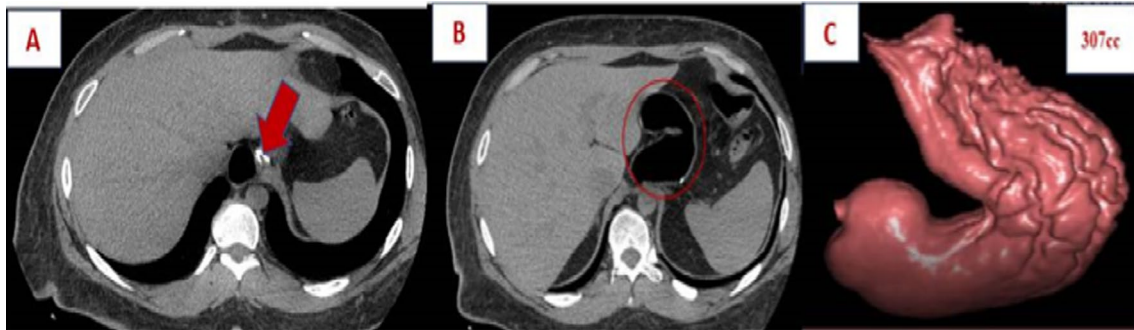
A 44-year-old obese female (BMI = 55.5) with postoperative gastric pouch volume is 307 cc. Preoperative weight and 1-year postoperative weight were 164 kg and 90 kg, respectively. 1-year weight reduction percentage is 42.5%, and 1-year postoperative BMI is 30.4. Although postoperative gastric volume is high, the patient had successful postoperative weight loss after 1 year but the % of loss from the excess weight after 1 year is 76.2%, i.e., the gastric volume is high and the % reduction in excess body weight is low compared to patients with smaller gastric volume. A, B CT abdomen are showing staples (arrow) and gastric pouch (circle). C 3D CT gastric volumetry showing gastric volume of 307 cc
